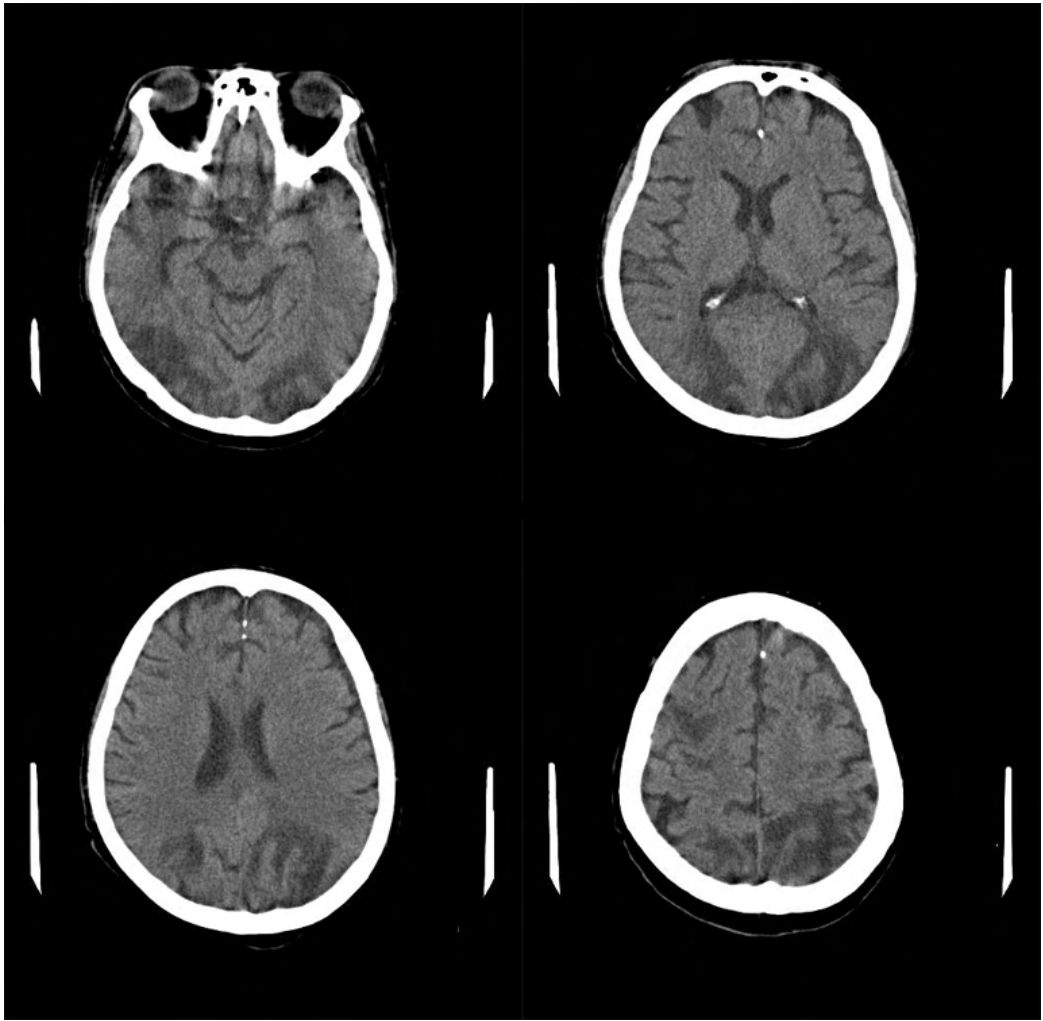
Axial cranial CT sections showing hypodensity compatible with vasogenic edema, affecting the occipital regions bilaterally in a symmetrical way, also affecting the frontal regions.
